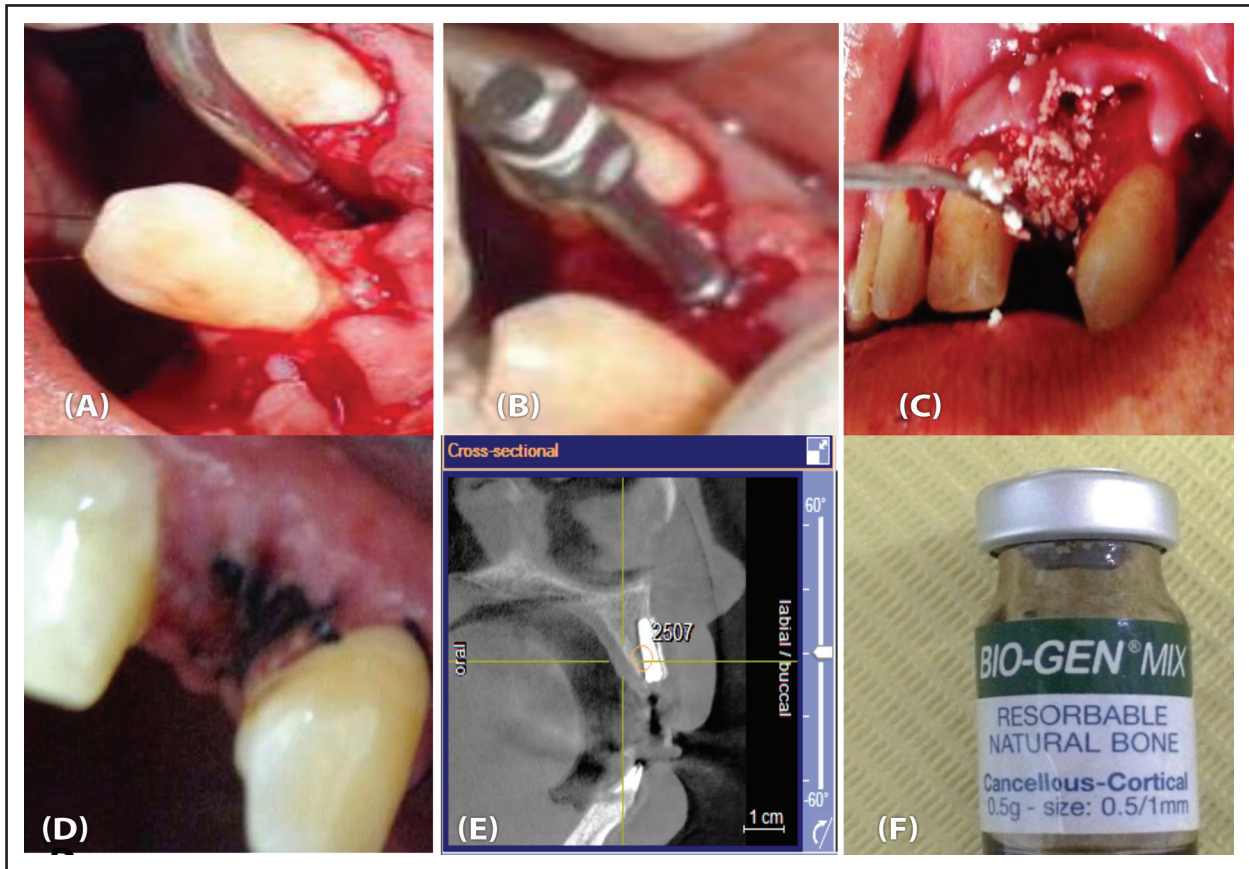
(BioGen) showing: (A) measuring the depth after initial drilling by pilot drill.(B) insertion of implant in alveolar ridge. (C) implant sealed with cover screw and BioGen bone graft. (D) post operative suturing. (E) CBCT bone density reading after nine months.
